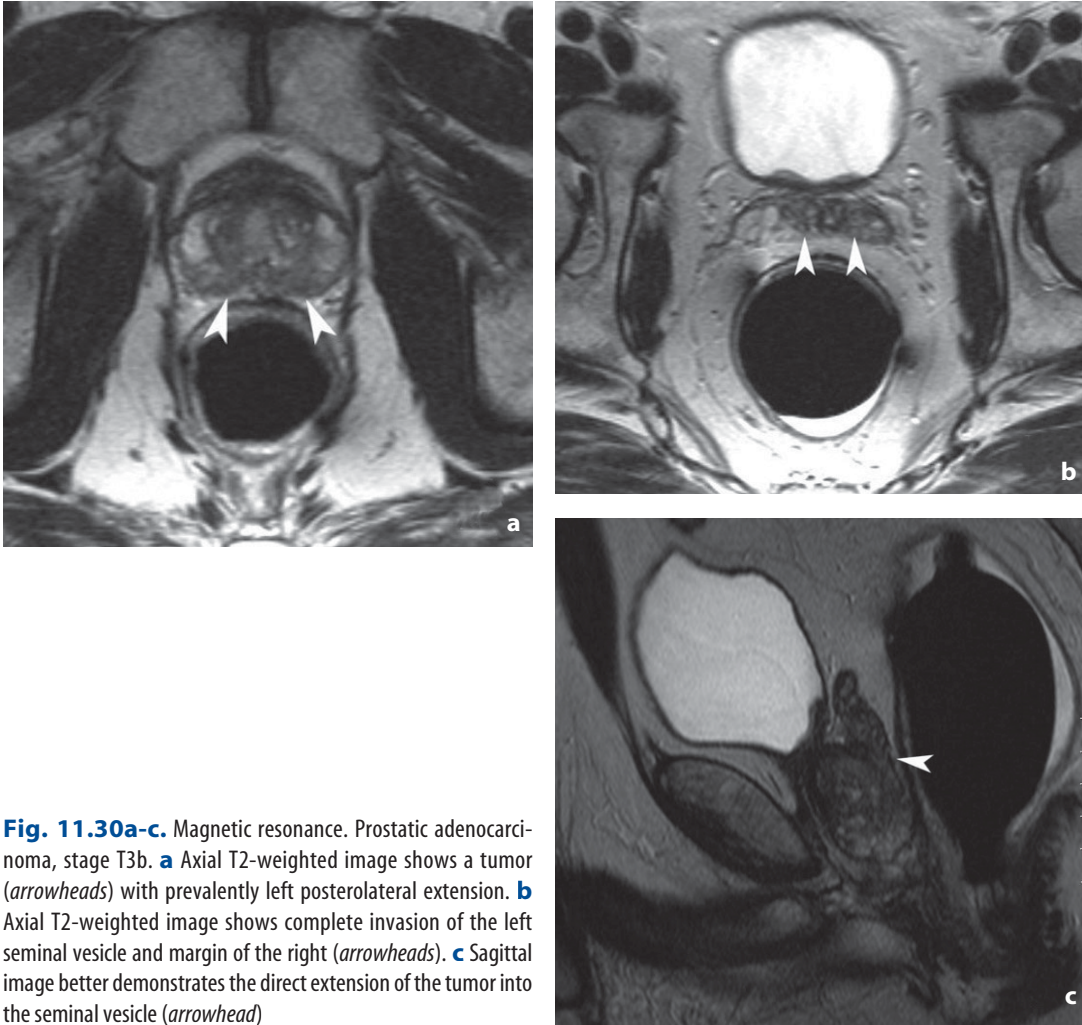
Magnetic resonance. Prostatic adenocarcinoma, stage T3b. a Axial T2-weighted image shows a tumor (*arrowheads*) with prevalently left posterolateral extension. b Axial T2-weighted image shows complete invasion of the left seminal vesicle and margin of the right (*arrowheads*). c Sagittal image better demonstrates the direct extension of the tumor into the seminal vesicle (*arrowhead*)
